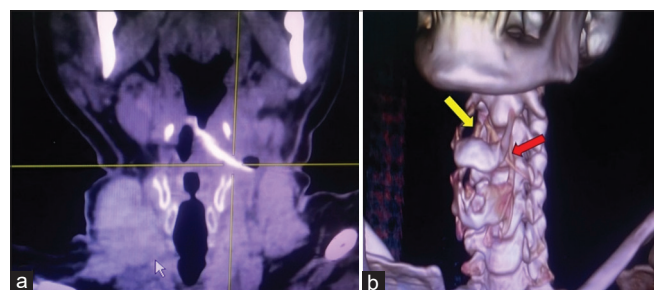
(a) Coronal section of computed tomography of head and neck showing the foreign body; (b) three-dimensional multiplanar reconstruction imaging of the neck showing the short segment (yellow arrow) and the long segment (red arrow) of the foreign body
